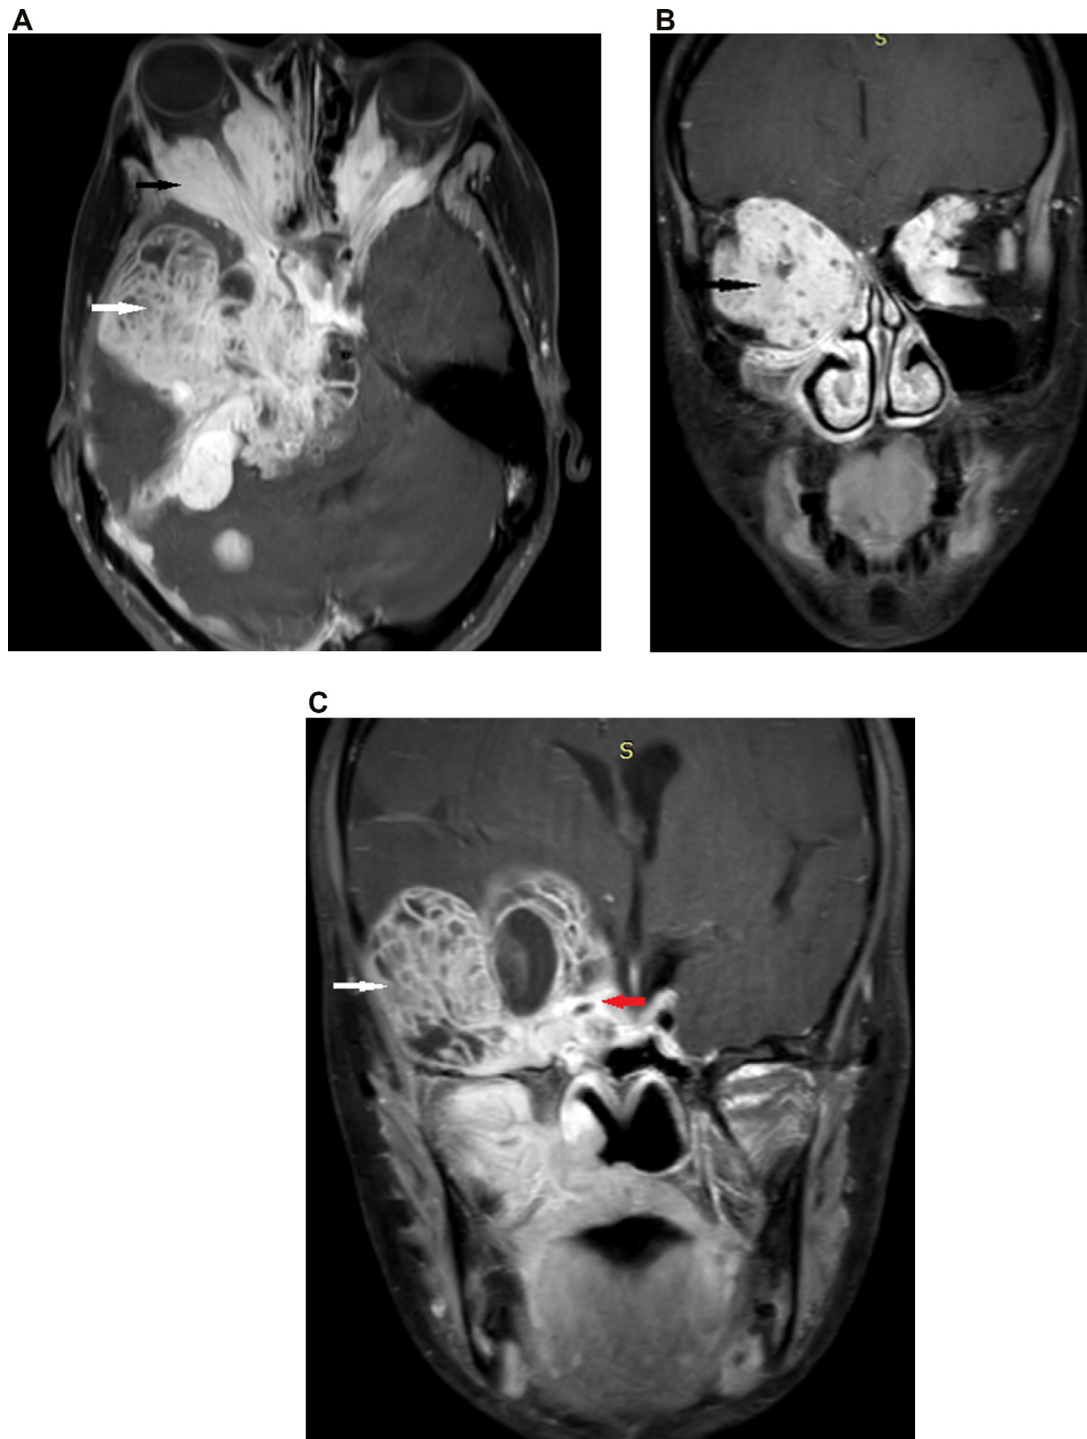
Orbitocerebral MRI, Axial (a) and coronal (b) of T1-weighted contrast-enhanced FAT suppressed sequences showing the extend of the tumor through the inferior orbital fissure into the orbit associated to the invasion of the right internal carotid artery, cavernous sinus, (red arrow) bilateral optic nerve marked in the right with homolateral grade 3 exophthalmos (black arrow). The tumor demonstrated an intracranial extension, in the right temporal responsible of a temporal herniation (white arrow). (Online version of figure is available online.)
